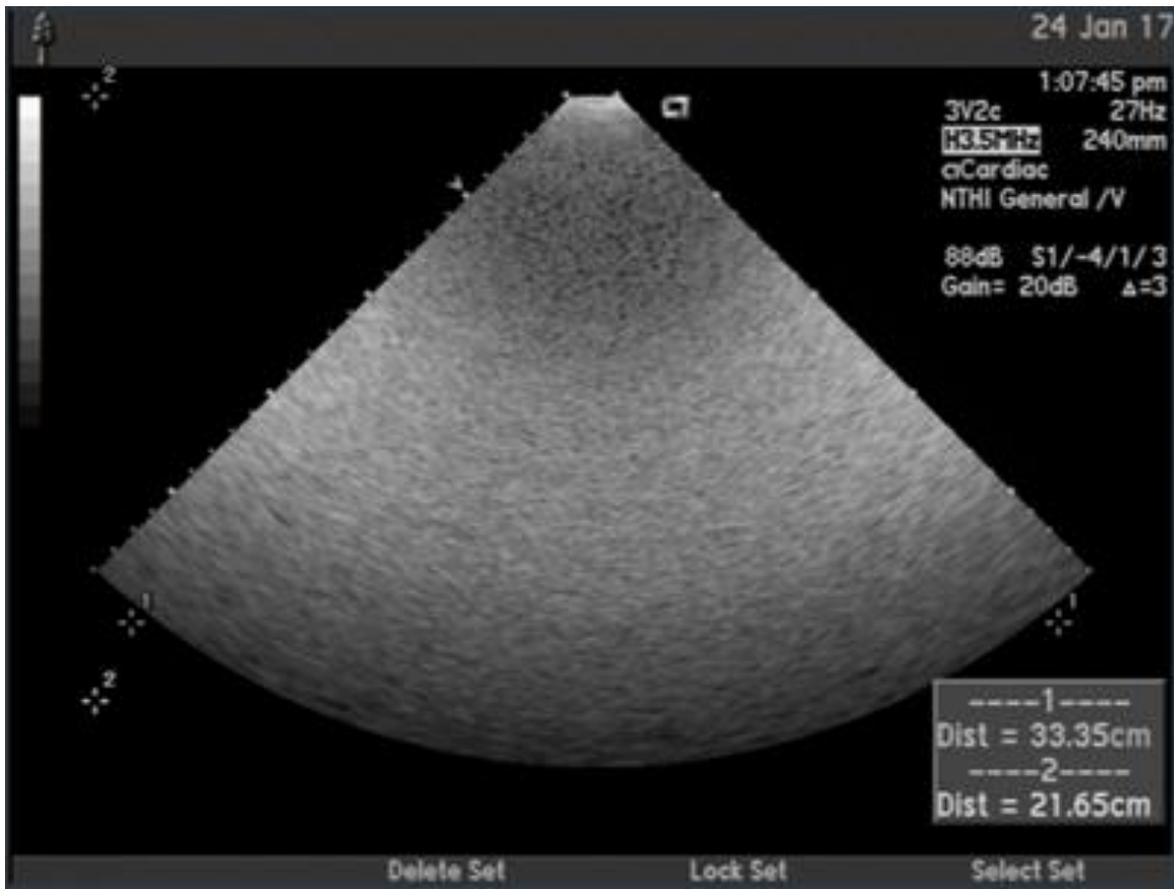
Ultrasound image on the Ultrasound Settings screen
